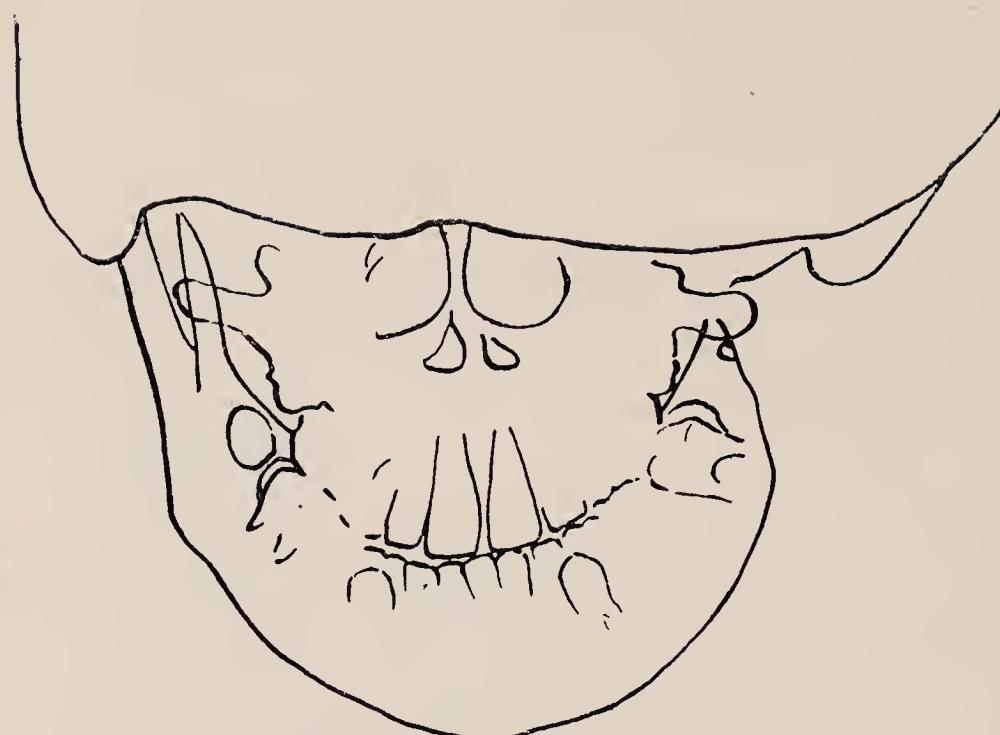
Tracing of radiograph showing failure of left mandibular ramus.
